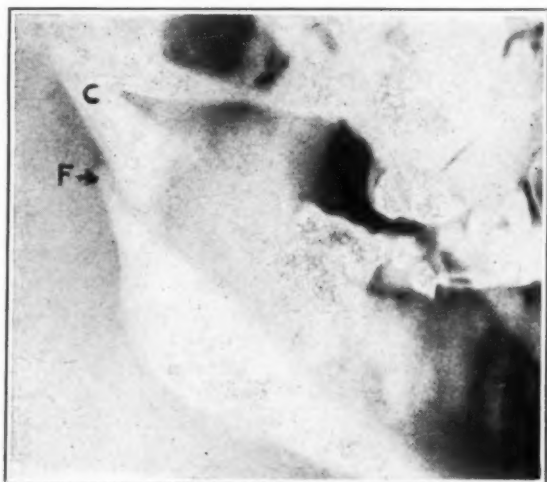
Case 5. Collum fracture, bilateral, with fracture at symphysis of mandible; the x-ray picture shows a fracture of the condyle on the left and right with forward displacement of neck and overriding due to muscular contraction. C, condyle; F, fracture line.
